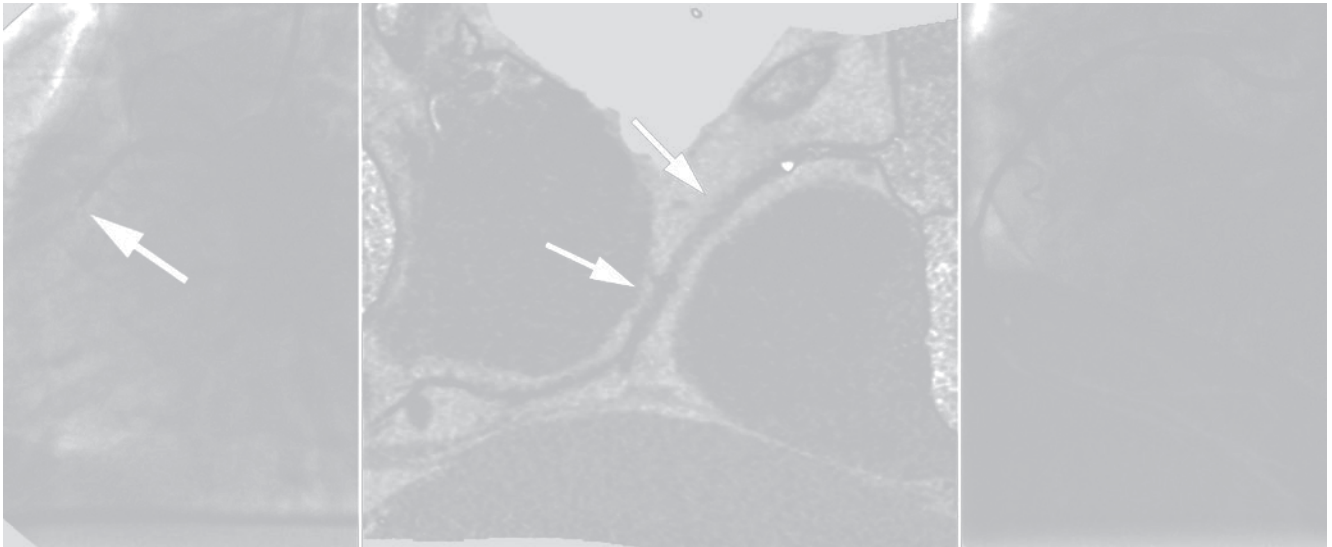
Typical findings of coronary CT angiography in patients with an acute coronary syndrome. (a) Coronary CT angiography (curved multiplanar reconstruction) shows three high-grade stenoses of the right coronary artery (arrows). (b) As frequently seen in acute coronary lesions, there is pronounced “positive remodeling” of the lesion, a consequence of plaque rupture with subsequent thrombus formation inside the vessel. (c) A cross-sectional view of the right coronary artery
